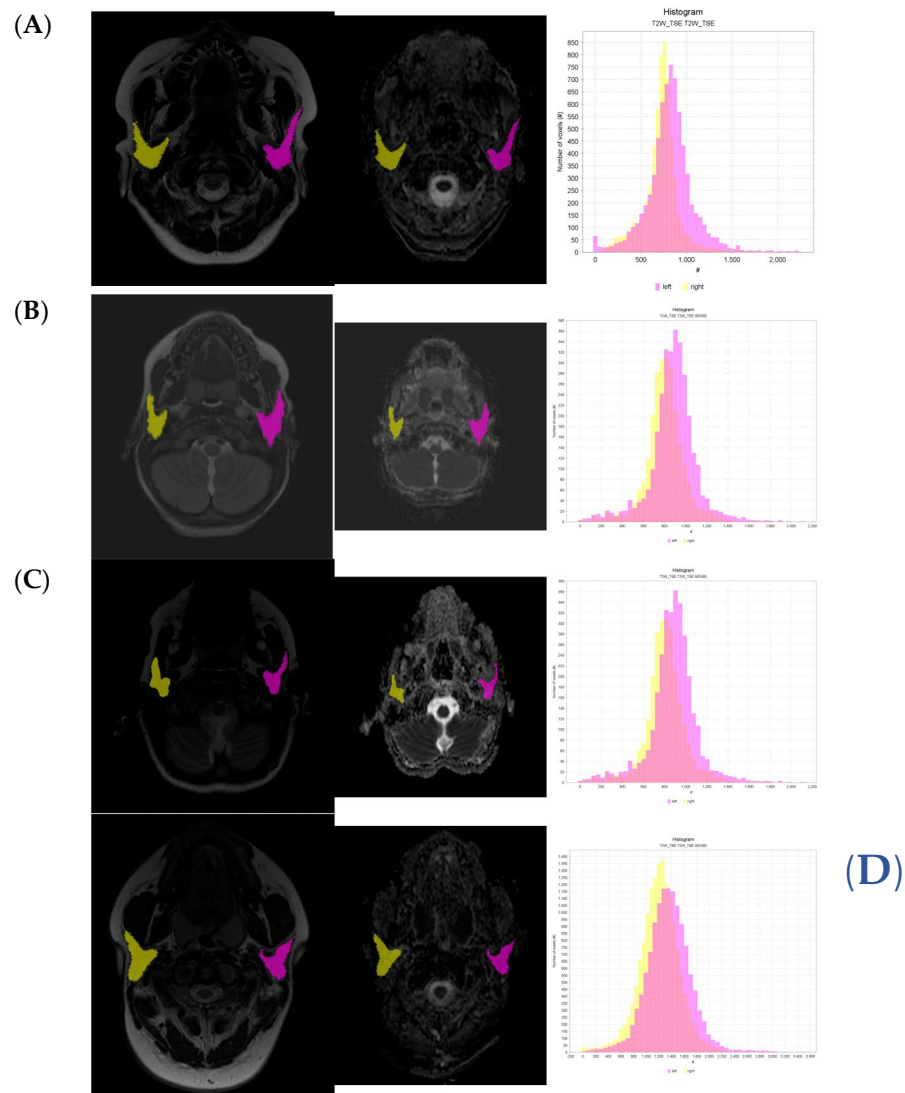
Axial images of T2-weighted imaging, diffusion-weighted imaging (DWI), and apparent diffusion coefficient (ADC). Histogram correlated with T2 images. For Tonami scale: (A) grade 0, (B) grade 1, (C) grade 2, (D) grade 3.
